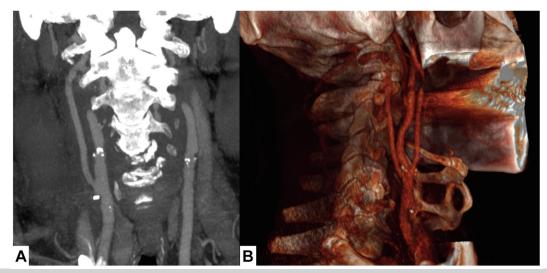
A, Multiplanar reconstruction of computed tomography angiography (CTA) at 6 months postoperatively showing patency of the venous bypass and distal vertebral artery (VA) revascularization. B, CTA with volume-rendering technique reconstruction revealing three-dimensional anatomic relations of the distal anastomosis between the transverse processes of the first and second cervical vertebrae.
